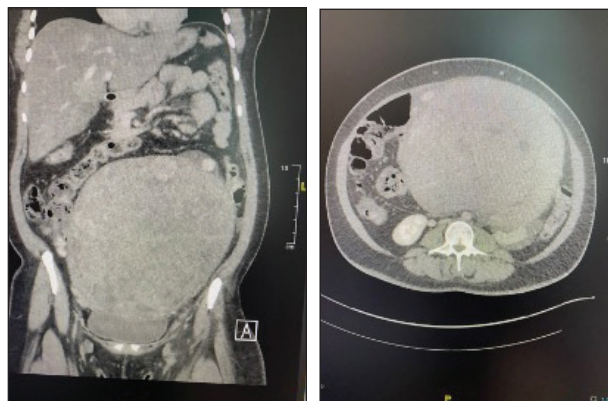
Preprocedure CT scan.
